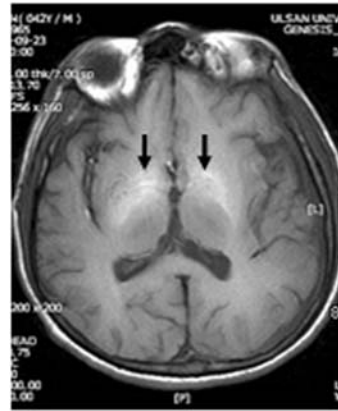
Axial section showed symmetrical high signal intensities in the globus pallidus on T1-weighted magnetic resonance images (MRI) (arrows).
